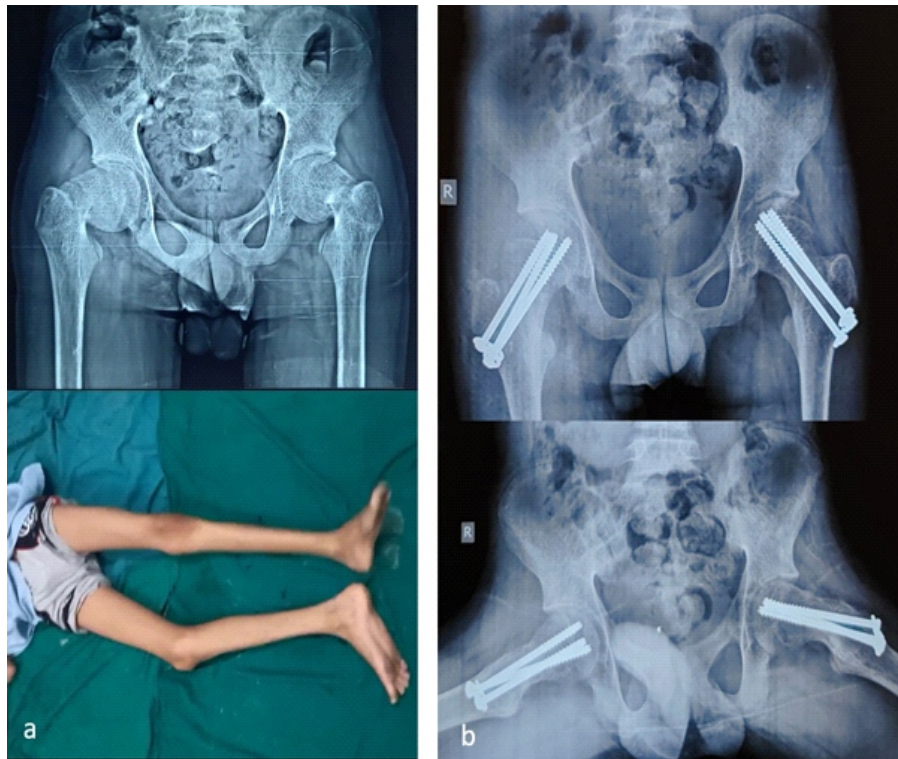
a. Bilateral displaced fracture neck femur in M/15 years (Patient no 33) brought on stretcher with bilaterally rotated limbs, b. X-rays after three months showed bilateral union without any complications
